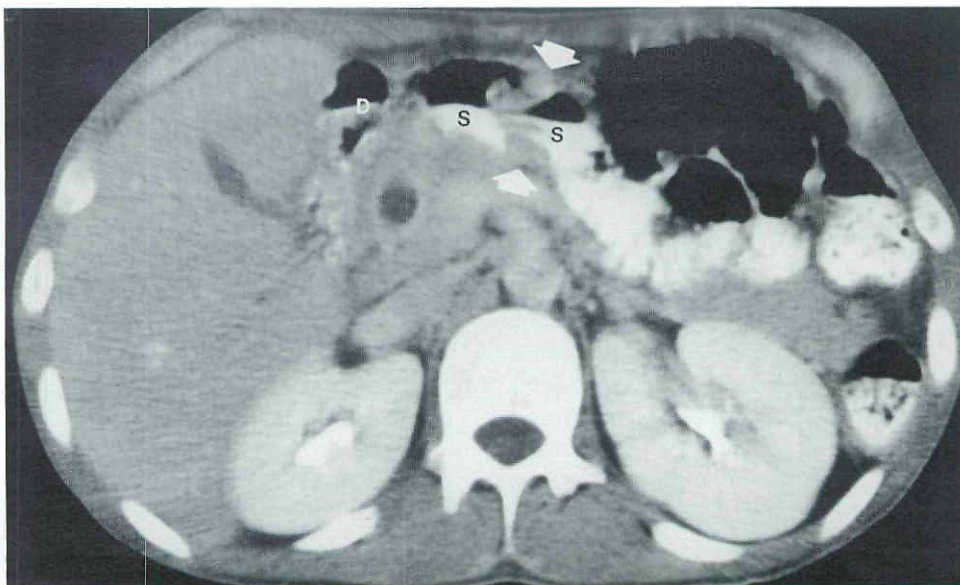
Representative cut from CT scan showing antral mass (arrows) S, stomach; D, duodenum.
